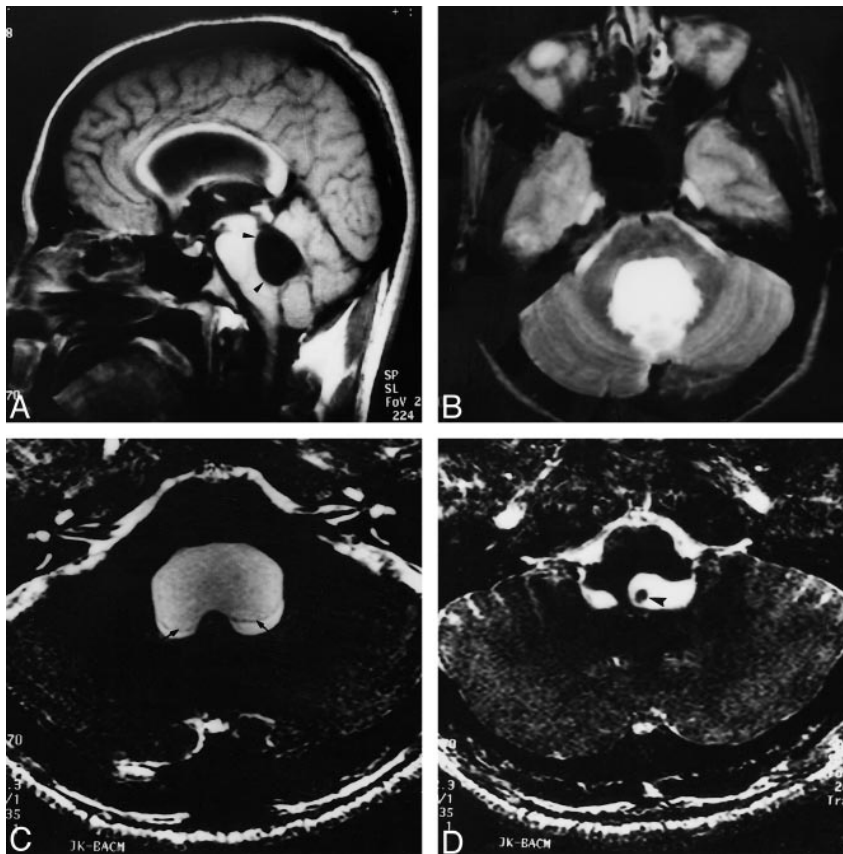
A and B, Sagittal SE T1-weighted (650/14/1) (A) and axial T2-weighted (3800/90/2) (B) images show a dilated fourth ventricle (arrowheads). No cyst is seen.
